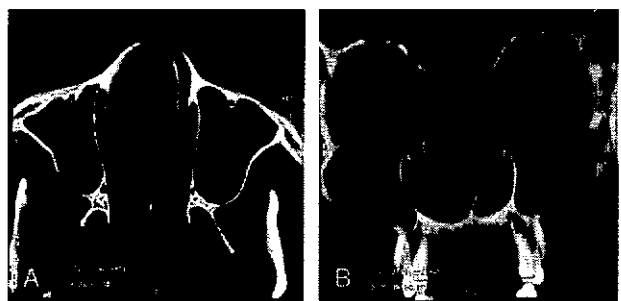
Computed tomographic scan of the nose and the paranasal sinuses axial (A) and coronal (B) views shows concha bullosa mucopyocele that fills the right nasal cavity.
